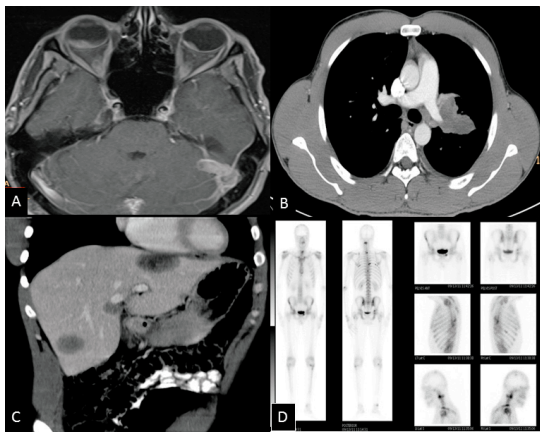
A- Orbit MRI axial, T1 WI's post contrast image showing soft tissue nodular lesions in the posterior parts of the eye globes mainly at the right side, demonstrating homogeneous contrast enhancement. B- Enhanced CT scan of the chest; mediastinal window shows left hilar soft tissue mass encasing the left main pulmonary artery. C- CT scan through the liver shows multiple hypodense liver lesions represent metastases. D- Bone scan demonstrates multiple active bone lesions represent metastases.
